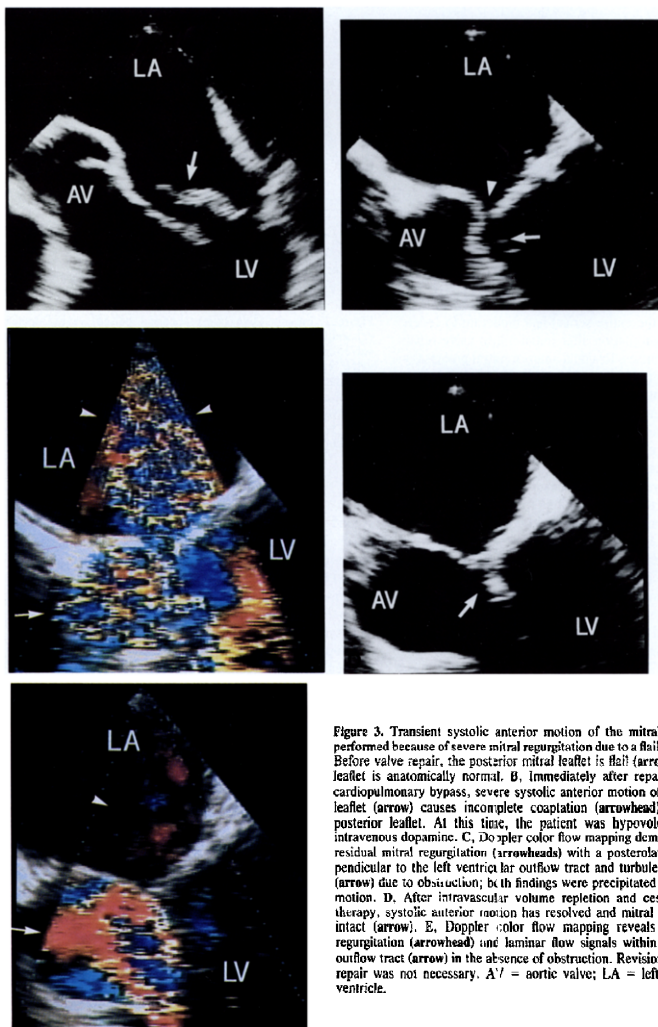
Transient systolic anterior motion of the mitral valve after repair performed because of severe mitral regurgitation due to a flail posterior leaflet. A. Before valve repair, the posterior mitral leaflet is flail (arrow) and the anterior leaflet is anatomically normal. B. Immediately after repair and cessation of cardiopulmonary bypass, severe systolic anterior motion of the anterior mitral leaflet (arrow) causes incomplete coaptation (arrowhead) with the plicated posterior leaflet. At this time, the patient was hypovolemic and receiving intravenous dopamine. C. Doppler color flow mapping demonstrates significant residual mitral regurgitation (arrowheads) with a posterolateral trajectory perpendicular to the left ventricular outflow tract and turbulent flow in this tract (arrow) due to obstruction; both findings were precipitated by systolic anterior motion. D. After intravascular volume repletion and cessation of inotropic therapy, systolic anterior motion has resolved and mitral leaflet coaptation is intact (arrow). E. Doppler color flow mapping reveals no residual mitral regurgitation (arrowheads) and laminar flow signals within the left ventricular outflow tract (arrow) in the absence of obstruction. Revision of the mitral valve repair was not necessary. A/V = aortic valve; LA = left atrium; LV = left ventricle.
